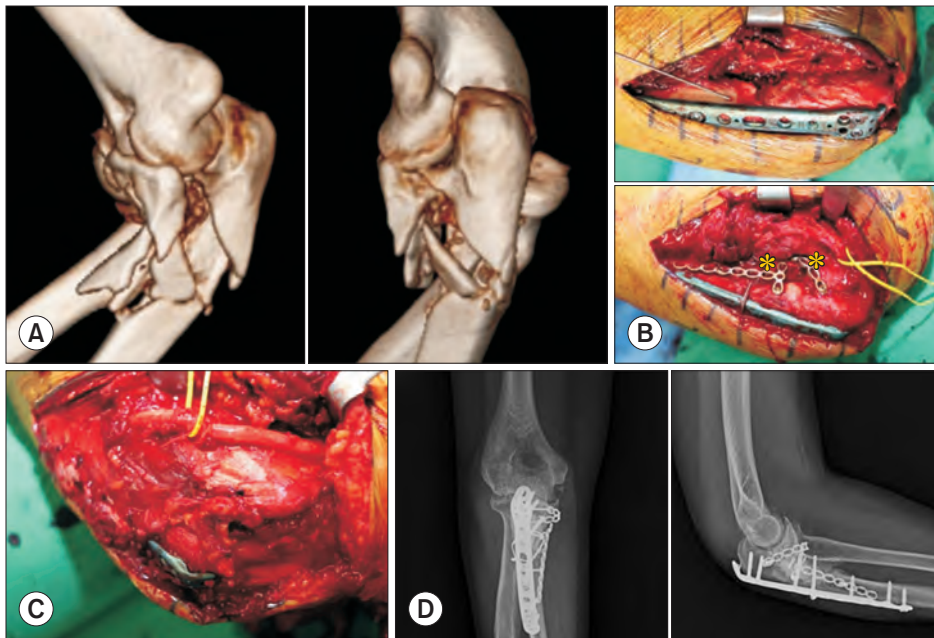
A 64-year-old woman classified as having a type 3 trans-ulnar basal coronoid fracture-dislocation. (A) Three-dimensional computed tomography reconstruction of the type 3 trans-ulnar basal coronoid fracture-dislocation. (B) After the olecranon fracture was reduced and fixed with a plate, the Taylor–Scham approach was utilized. The base and anteromedial facet fragment fractures were fixed with wiring and 2 miniplates (asterisks). (C) Ulnar nerve anterior transposition was performed at the last stage of surgery. (D) Postoperative anteroposterior and lateral radiographs at 6 months after surgery.
